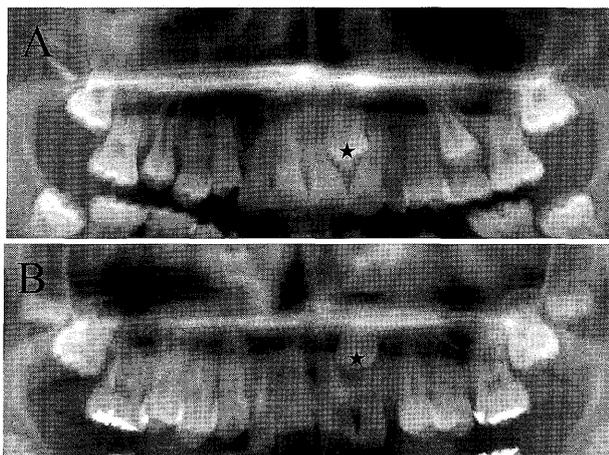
The initial orthopantomograms in Cases 7 and 8 of types B
